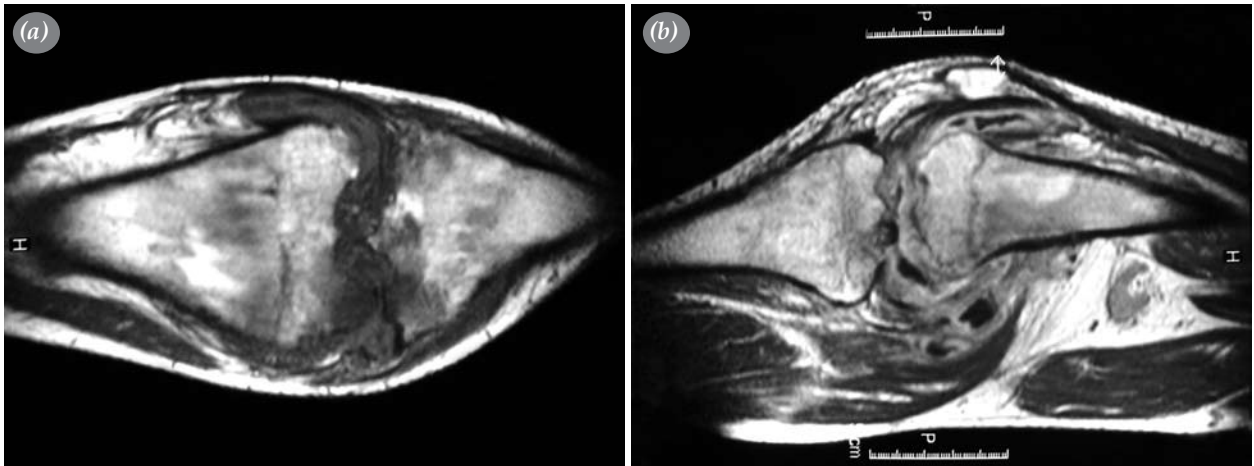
(a) T₁-weighted coronal magnetic resonance image. Cortical irregularity and abnormal hypointense signals on para-articular bony structures. (b) T₁-weighted magnetic resonance image shows hypertrophy, thickening and intense contrast enhancement on synovium which extends extra-articularly.
